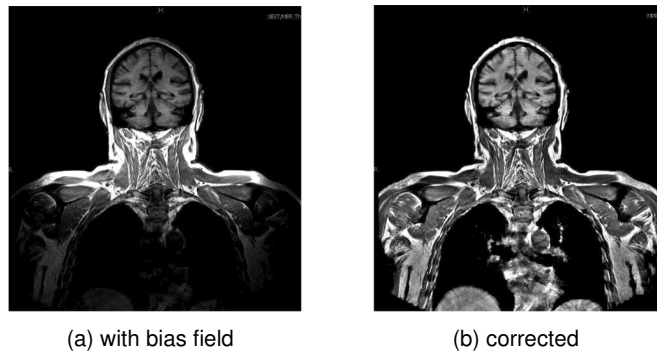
MRI intensity inhomogeneity (Courtesy of F. Jäger)
